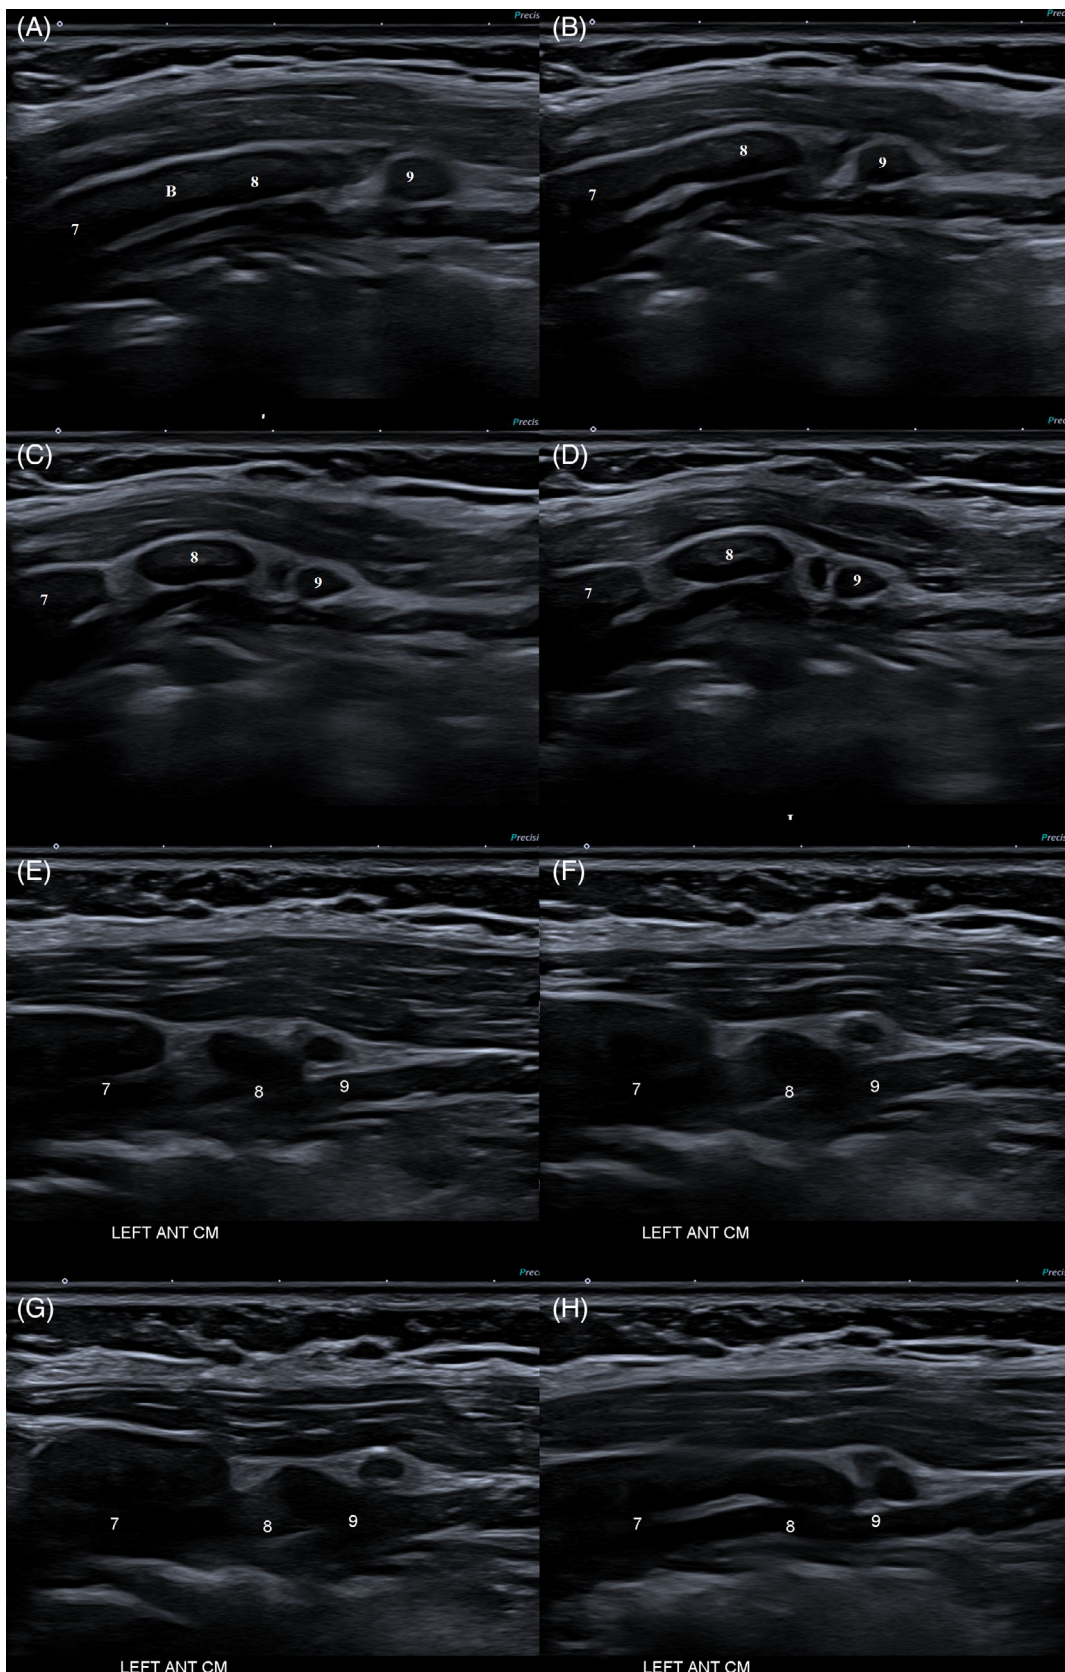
Subtle excessive excursion of a chondral rib tip. A-D, sagittal ultrasound of the left anterior costal margin demonstrates subtle hypermobility of the 9th rib tip. It is being forced posteriorly and compressing the intercostal tissues. Of note, there is a chondral bridge between the 7th and 8th rib at this level which is theorised to provide a rigid point on which the inferior rib is forced against. E-H, The 9th rib tip appears to be “floating” in a circular motion during provocation testing, implying inadequacy of the fibrous attachment. B = chondral bridge
